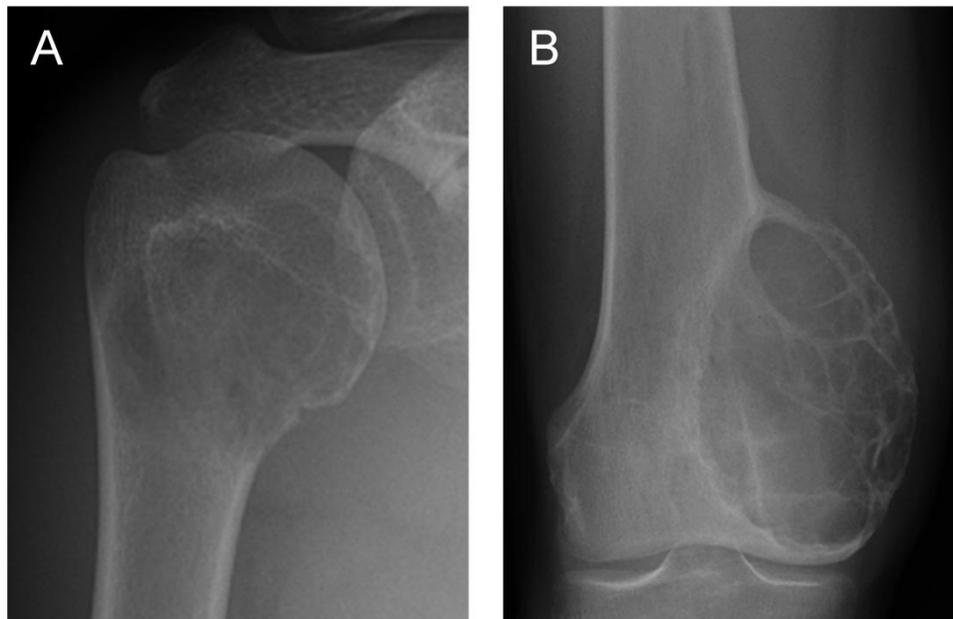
X-ray images from two patients presenting with GCT. Images show GCTs in the (A) proximal humerus and (B) distal femur.
